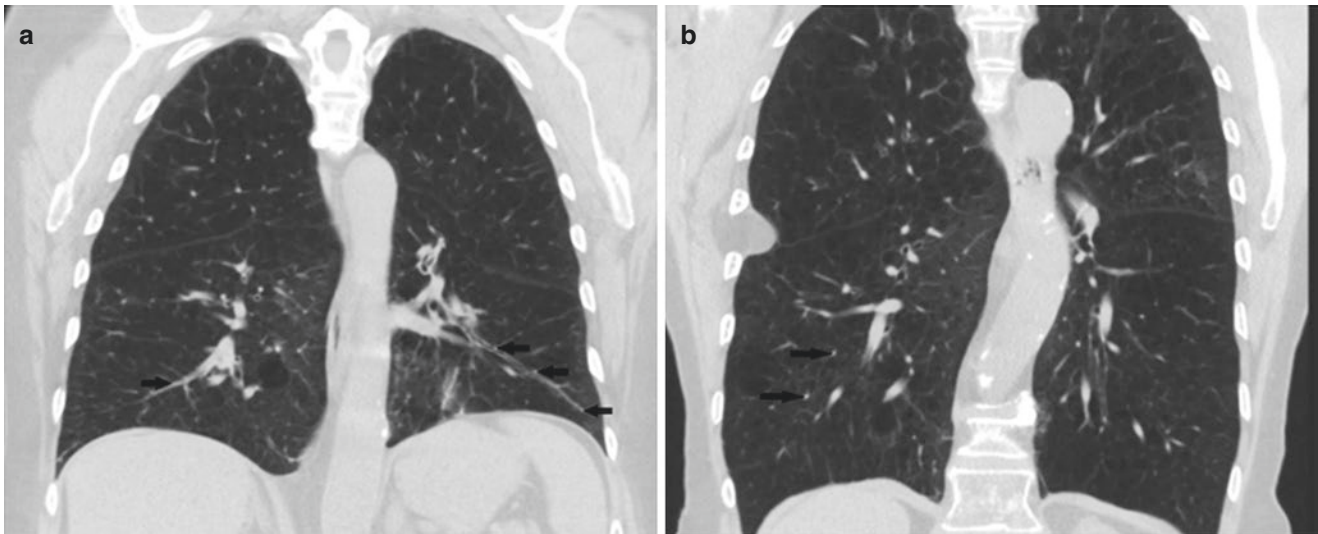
CT findings in DIPNECH and carcinoid tumorlets. The presence of multiple nodules arranged linearly along the walls of bronchi and bronchioles bilaterally is characteristic of DIPNECH (a). Carcinoid
